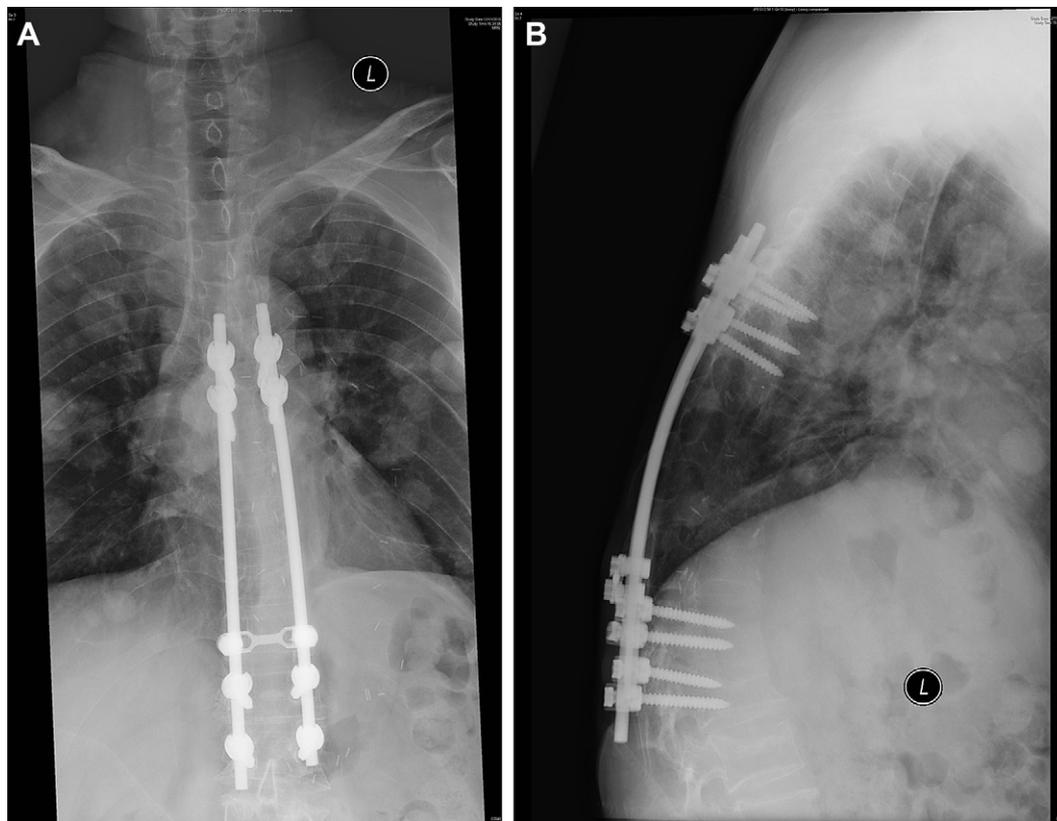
The postoperative (A) anteroposterior and (B) lateral radiographs of the thoracolumbar spine.
